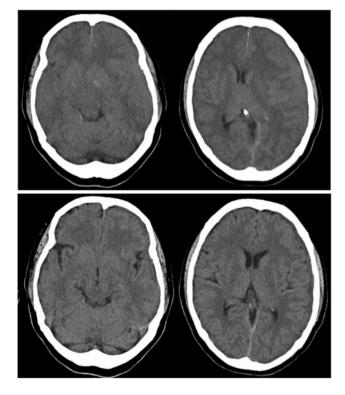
Brain computed tomography showing subdural hematoma on the left side and compression of the left ventricle with a midline shift on admission (upper), and resolution of the subdural hematoma with normalization of the left ventricle after treatment (day 25) (lower).
